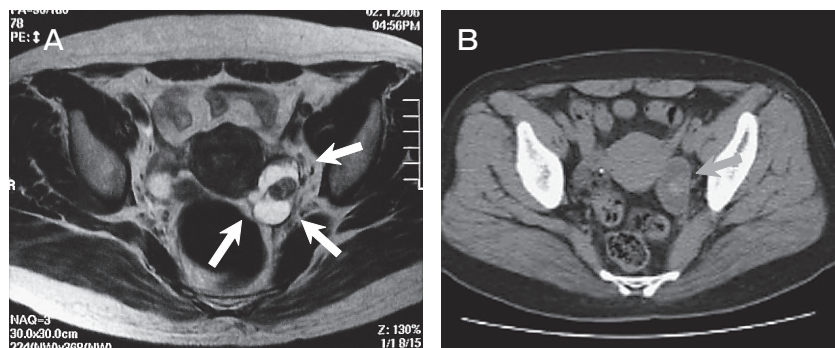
A, Pelvic MRI (case 1): Variable signal intensity on T2-weighted image. Horizontal section; B, (case 1): Plain CT shows 4.5 cm cyst on the left ovary with intracystic high-attenuation lesion.
